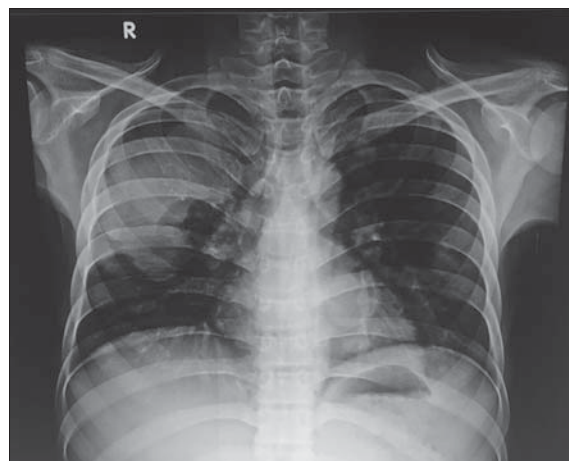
Chest X-ray demonstrating a heterogeneous opacity in the right upper zone of the lung
